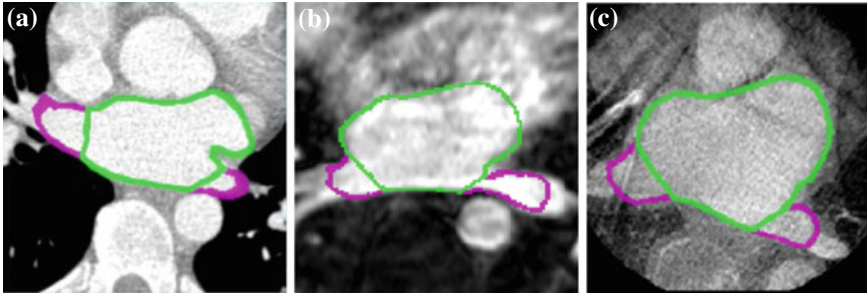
Exemplary results for LAPV segmentation in a CT (a), MR (b) and RXA (c) image (see [54, 55])
